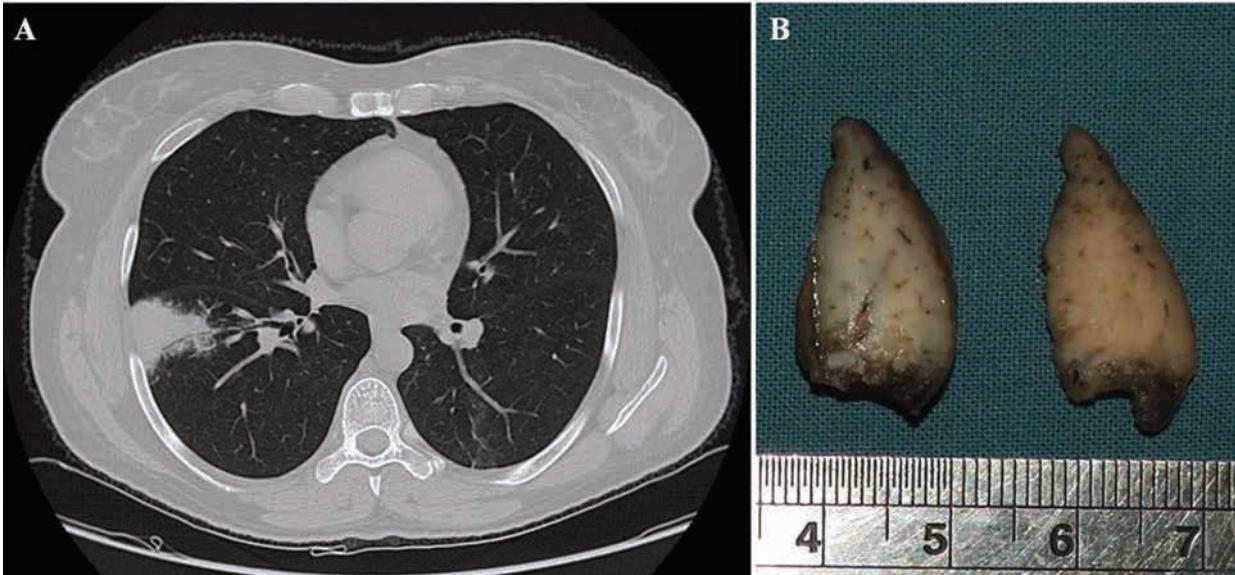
Gross changes in the lungs. A, Computed tomography scan of the lungs. Note the peripheral pathological focus. B, Gross view of the resected tissue showing consolidation.
